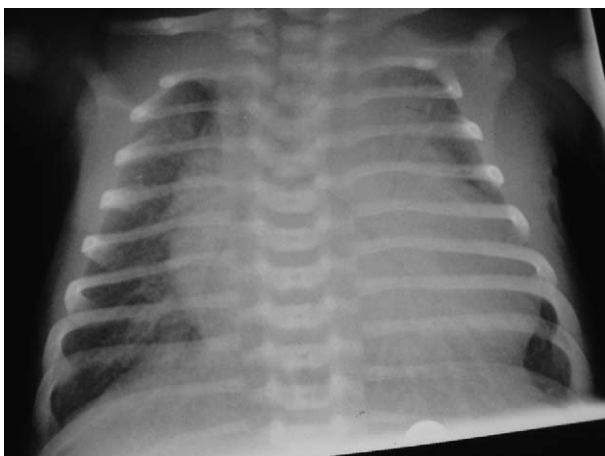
Typical chest X-ray (CXR) findings in neonatal aortic coarctation—pulmonary venous congestion and cardiomegaly (biventricular hypertrophy).
